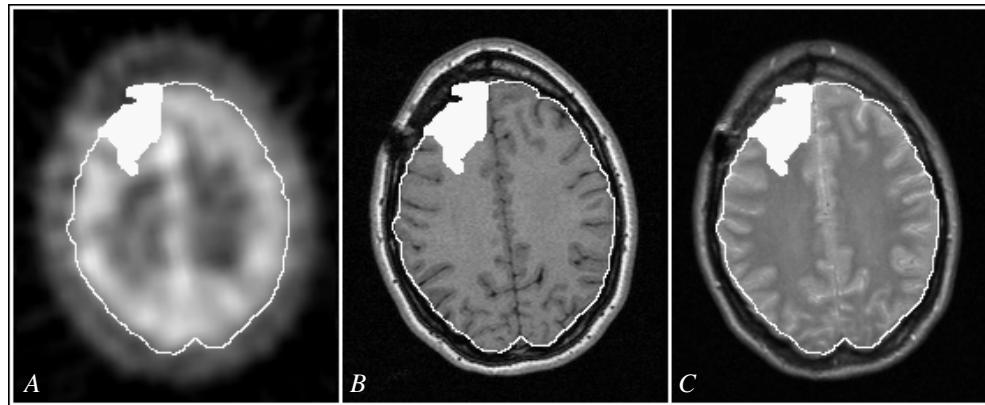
Selective integration using manual segmentation. The brain contour drawn in the MR-T1 image (B) and the damaged region rendered white in the MR-T2 image (C) are transferred to the corresponding SPECT image (A).
